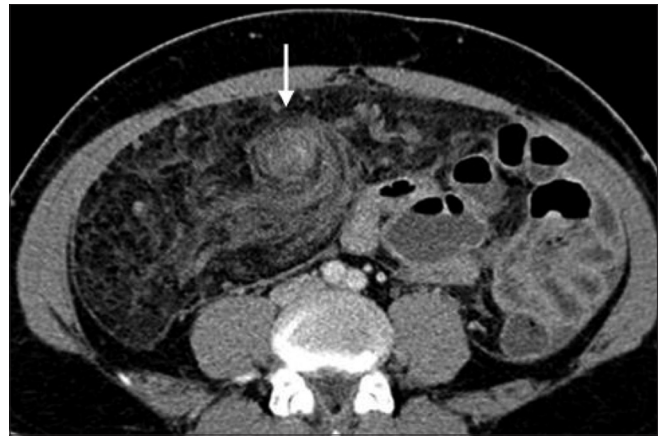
A contrast-enhanced CT scan shows a hazy right side of the greater omentum, with concentric hyperdensity (white arrow) and displacement of the bowel loops
